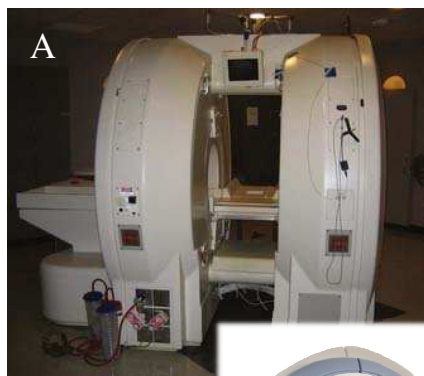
Different MRI configurations (A) General Electric “double donut” MRI [6], (B) Medtronic PoleStar MRI [6], (C) closed bore MRI [7] and (D) open MRI [8]
